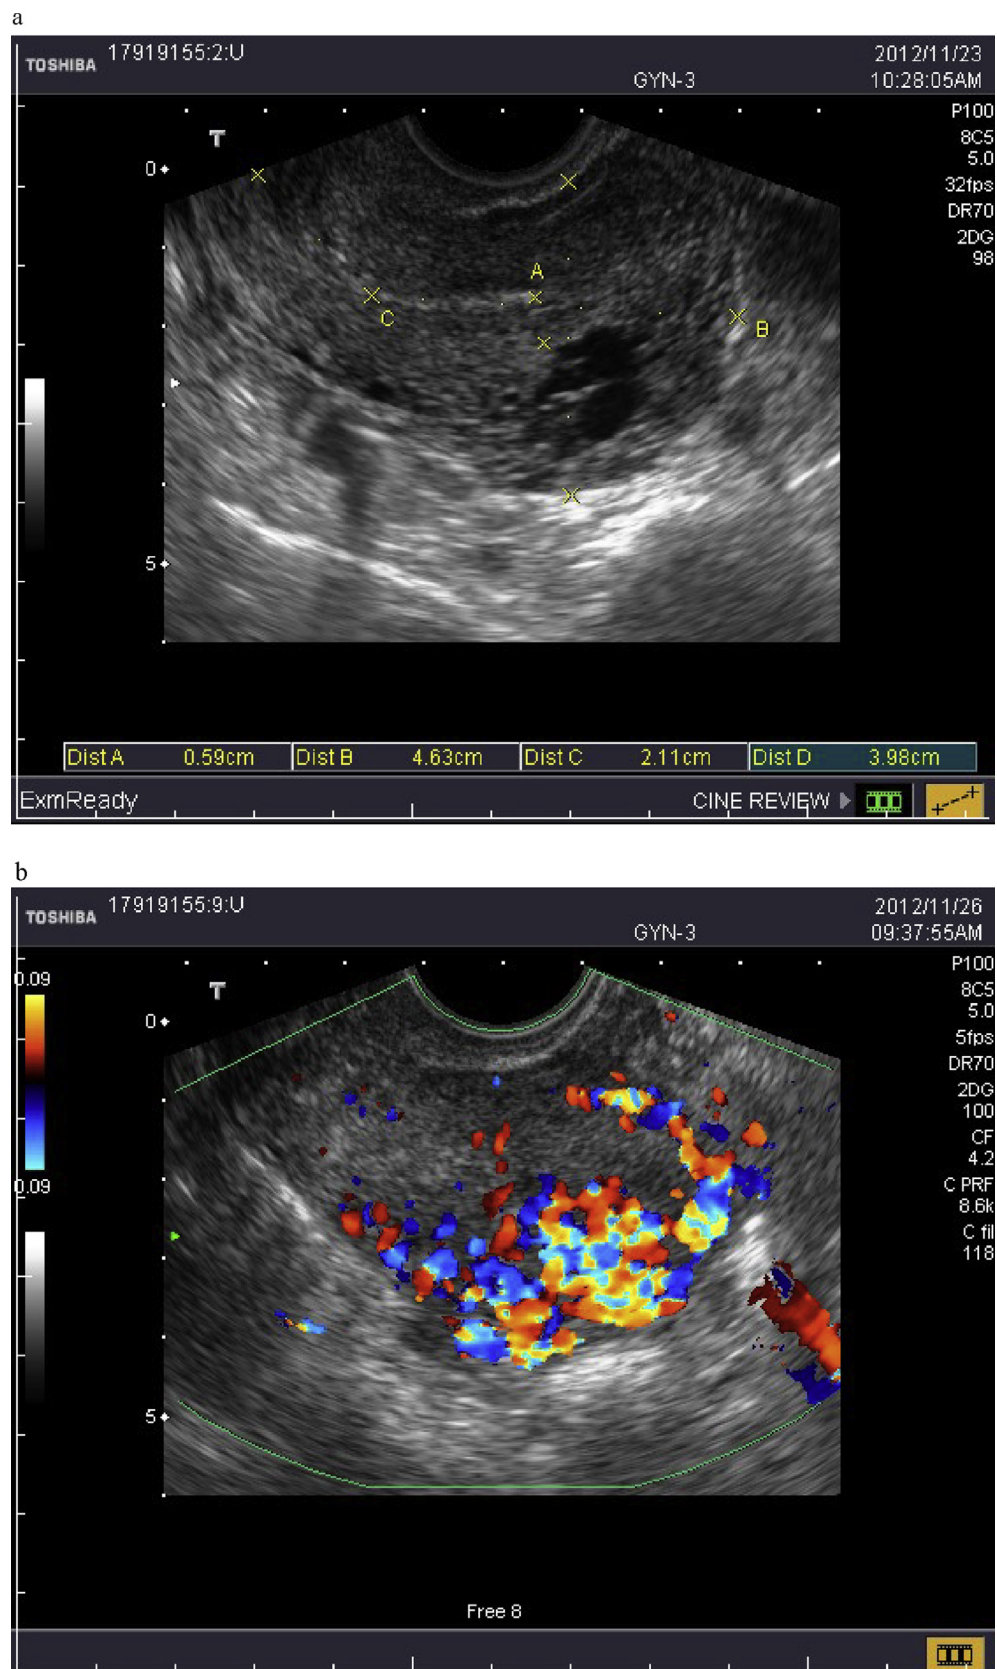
A bulging cystic mass with strong flow covered half the myometrium of uterus in case 3; a fireball in uterine wall (a: gray scale; b: Doppler color).
